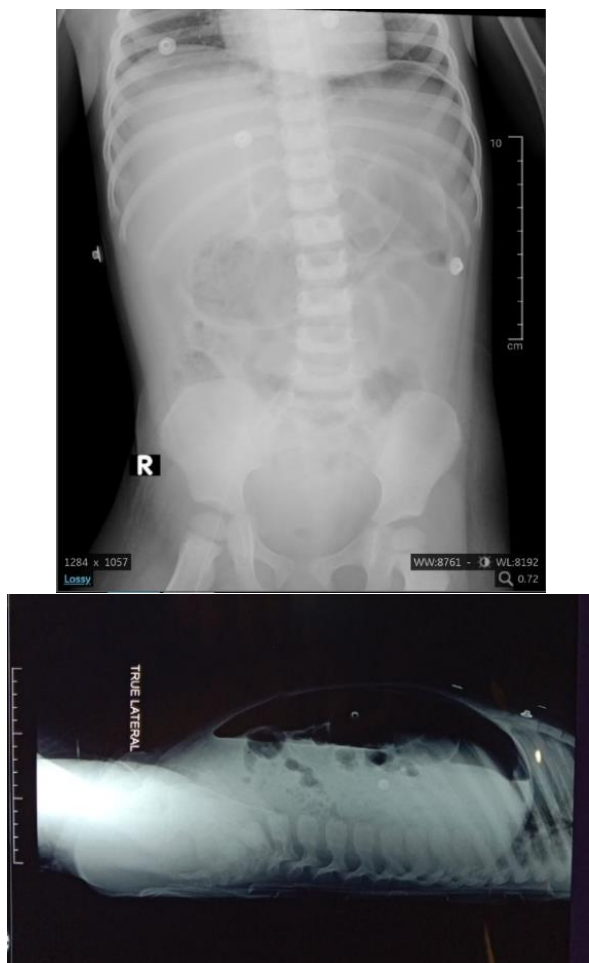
THE ABDOMINAL X-RAY SHOWED AN IMAGE OF THE BOWEL DISTENSION AND AIR-FLUID LEVELS
